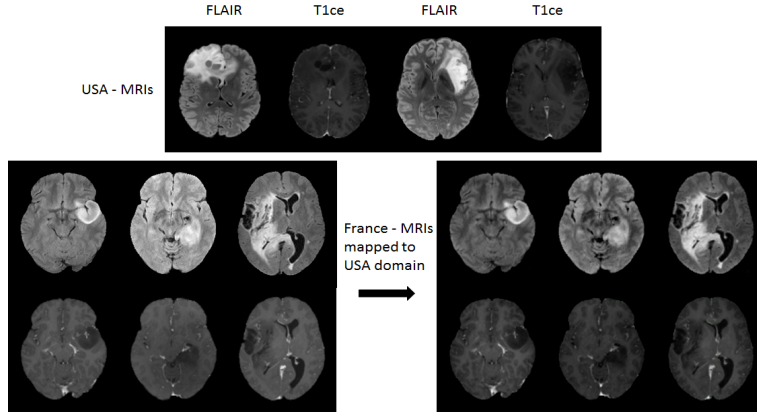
Visual inspection of 2D images for FLAIR-MRIs mapped from source domain to target domain.
